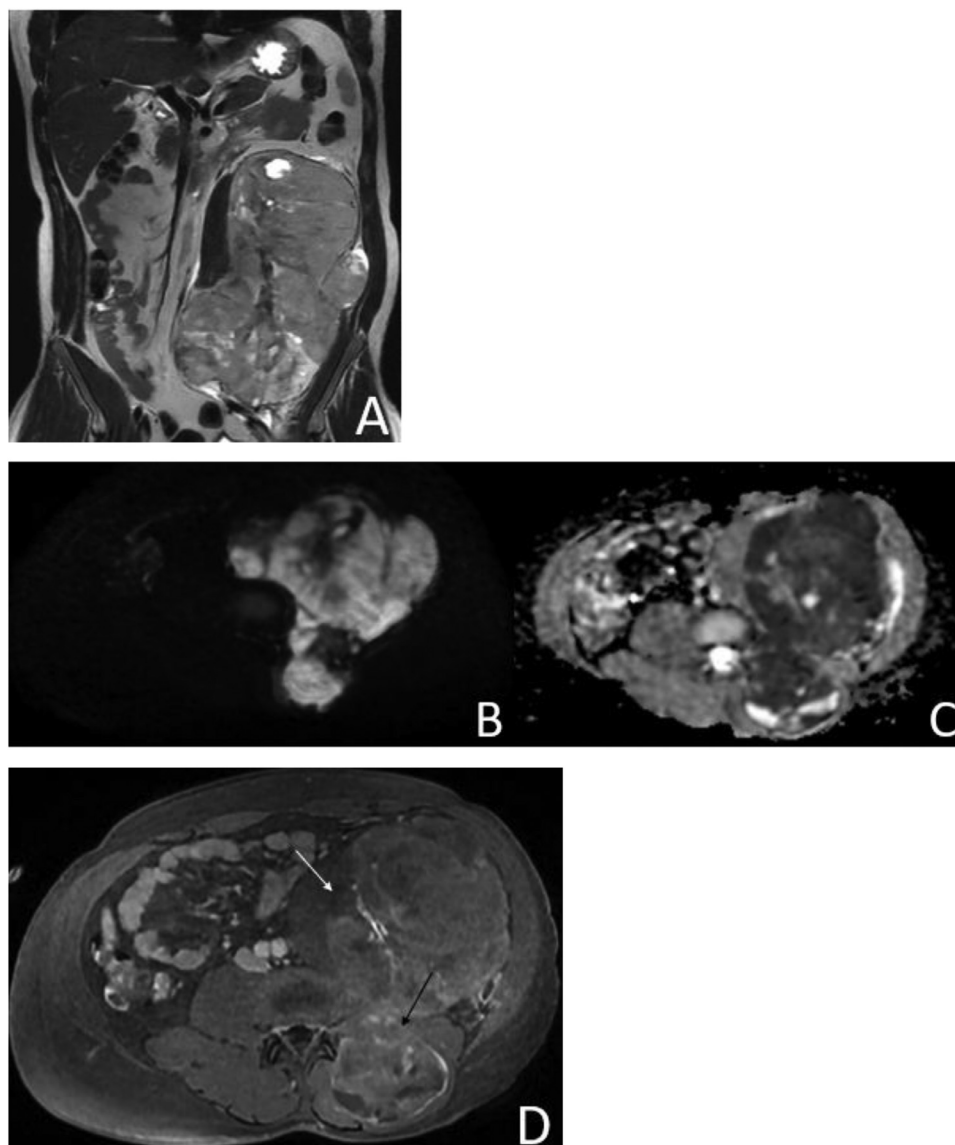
MRI images: (A) T2 coronal weighted imaging reveals a heterogenous mass with 3 different types of signal intensity also known as “triple sign”. (B and C) Axial DWI and ADC show the largest part of the tumor with marked diffusion restriction and a low ADC value. (D) Axial T1 fat-sat postgadolinium injection demonstrates an area with bright enhancement (black arrow) representing the solid part of the tumor, and a nonenhanced hypointense area representing the fluid part of the mass (white arrow).
